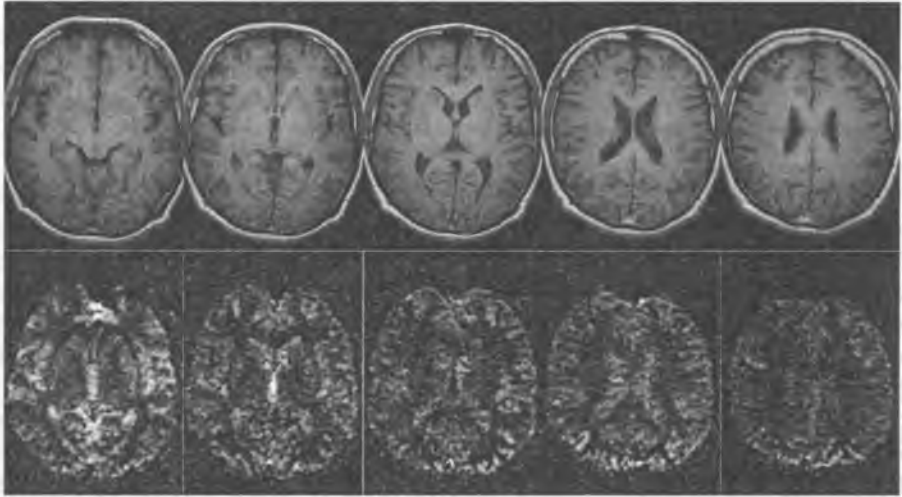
CASL CBF maps and T1-weighted MR images of a 34-year-old male
